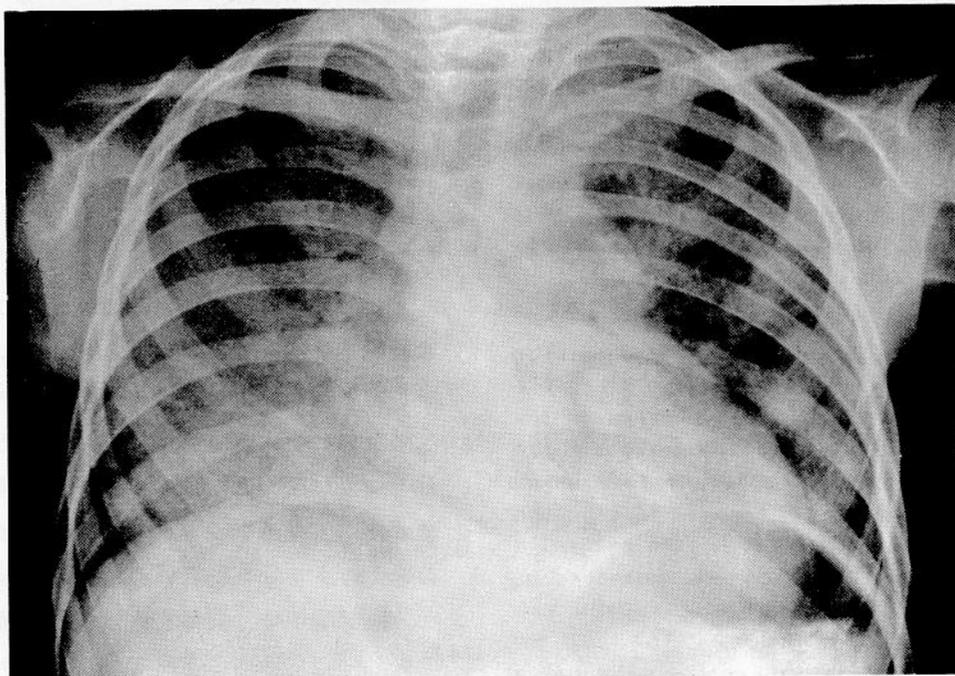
CHEST ROENTGENOGRAM MARCH 16, 1960 SHOWING DIFFUSE OPACIFICATION OF RIGHT LUNG FIELD AND MOTTLED LEFT LUNG FIELD DENSITIES
